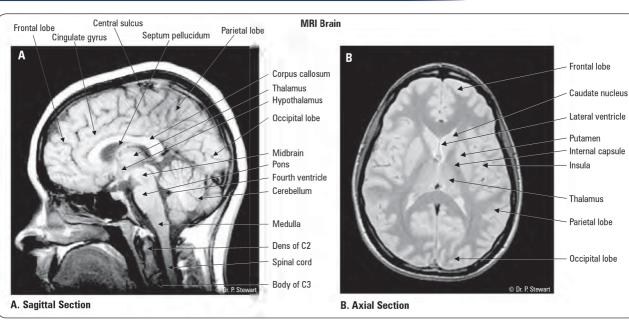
Magnetic resonance imaging (MRI) neuroanatomy Stewart P, et al. Functional Neuroanatomy (Version 2.1). Health Education Assets Library 2005
